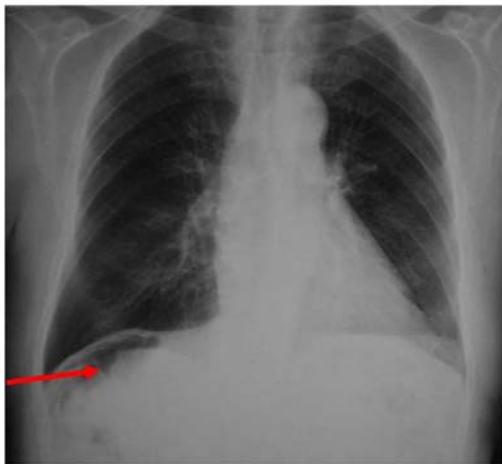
The chest x-ray reveals air collection below the right hemidiaphragm.
